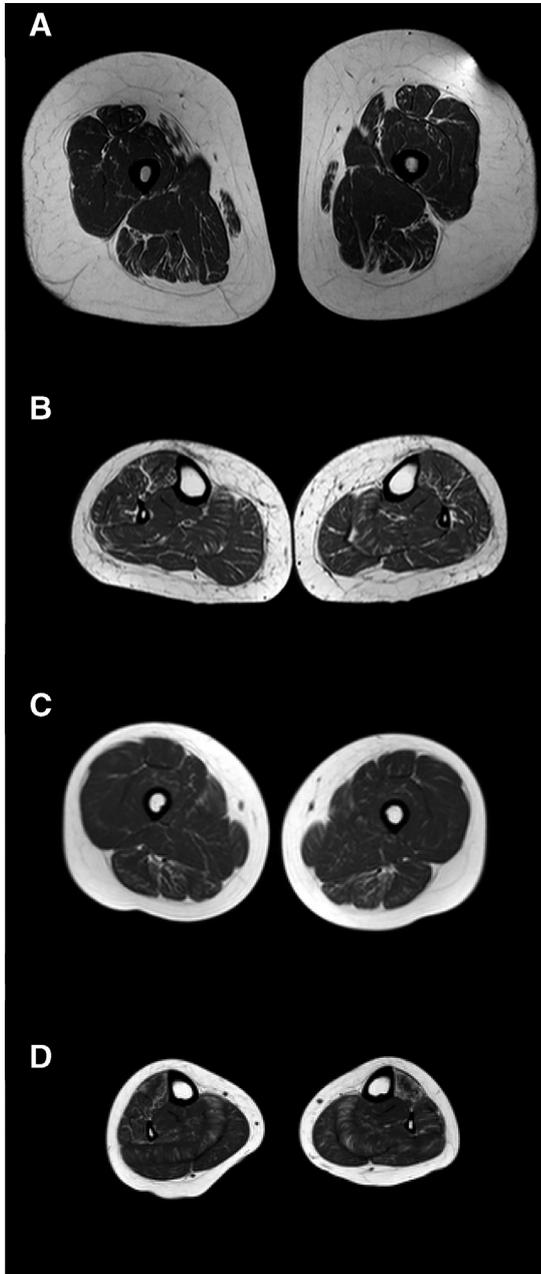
MRI of the mother shows atrophy and fatty replacement of the hamstring, vastus intermedius and rectus femoris on the thigh (A) and incipient signs of fatty infiltration in the tibialis anterior and peroneal muscles in the lower legs (B).
